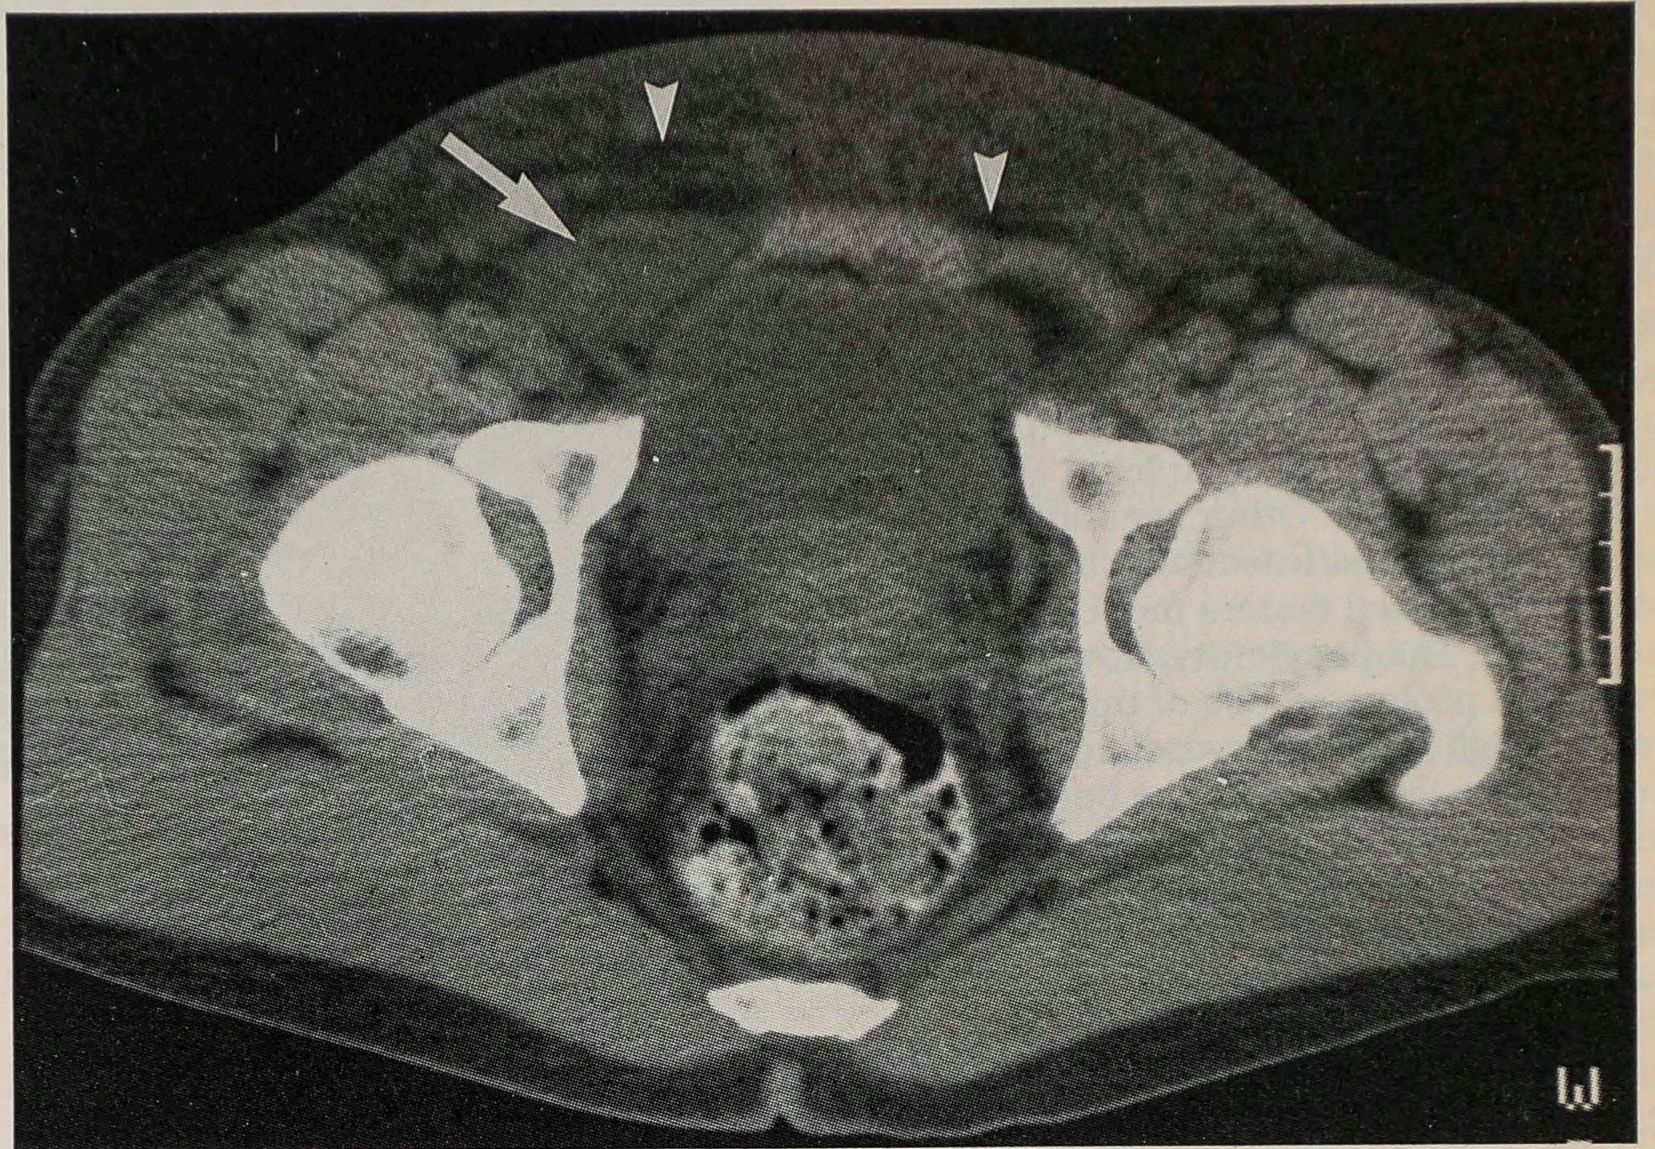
Case 1. Computed tomography scan identified mass in right inguinal canal (arrow). Edematous subcutaneous adipose tissue can be seen (arrowheads).
